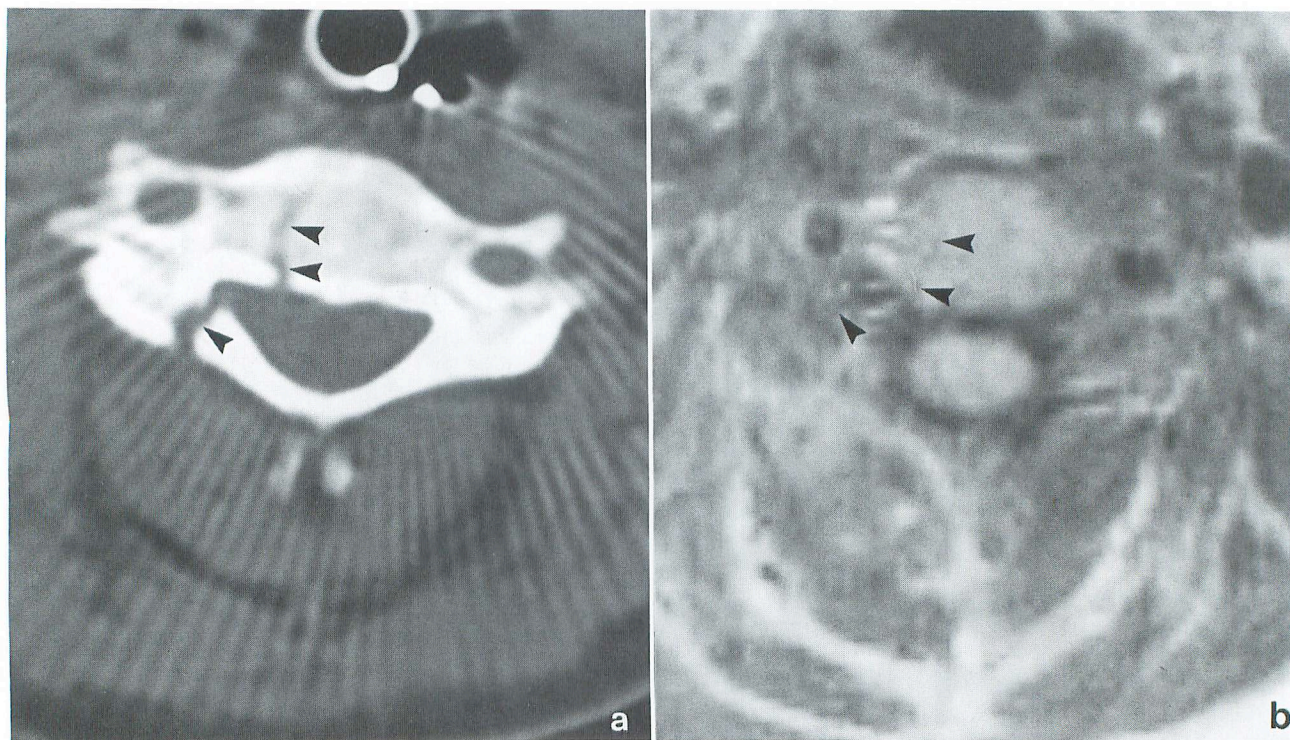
A 26-year-old male with multiple cervical vertebral fractures. a) CT scan demonstrates fractures of C4 body and lamina (arrowheads). b) T1-weighted SE image poorly demonstrates the fractures (arrowheads) due to the scarcity of resonating protons in the cortical bones. It is almost impossible to diagnose the bony fractures with this MR image
